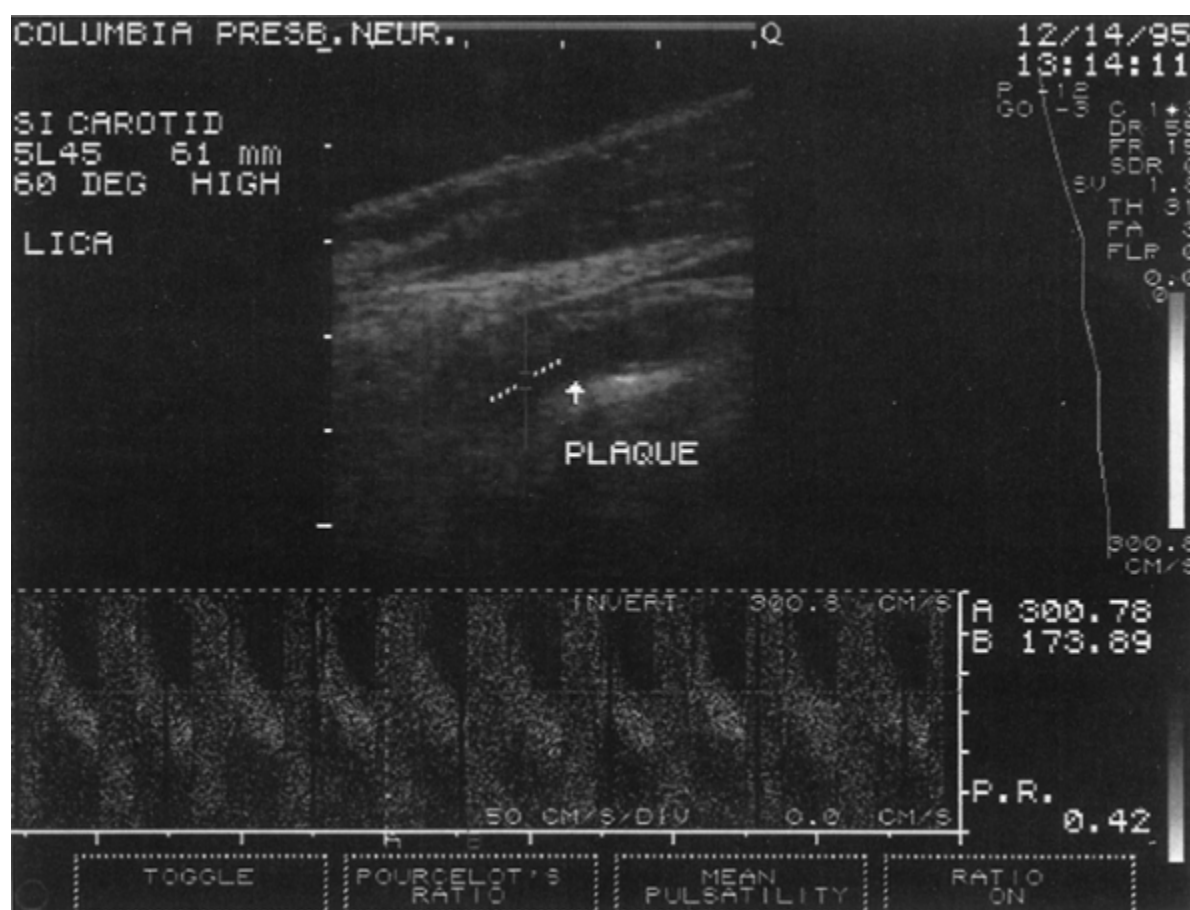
Duplex Doppler of the left internal carotid artery showing severe stenosis with plaque obstructing the lumen (*arrow*, upper). The Doppler wave form spectra confirm the hemodynamically significant stenosis (lower).
